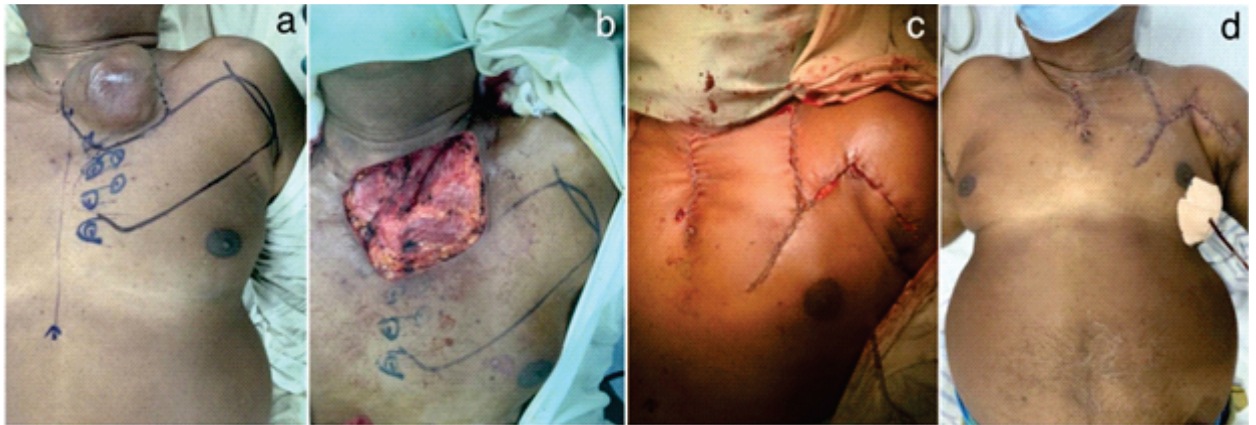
tographs of wide local excision(WLE) of lump and deltopectoral flap reconstruction; (a) The flap design and landmarks were drawn on the patient's skin. 2nd, 3rd and 4th perforator intercostal arteries were marked using doppler stethoscope. (b) Surgical wound following WLE of the lump. (c),(d)Final outcome of the patient. The donor site of the flap was closed directly by undermining the wound edges of the incision. Suction drains were fixed without air leak.
